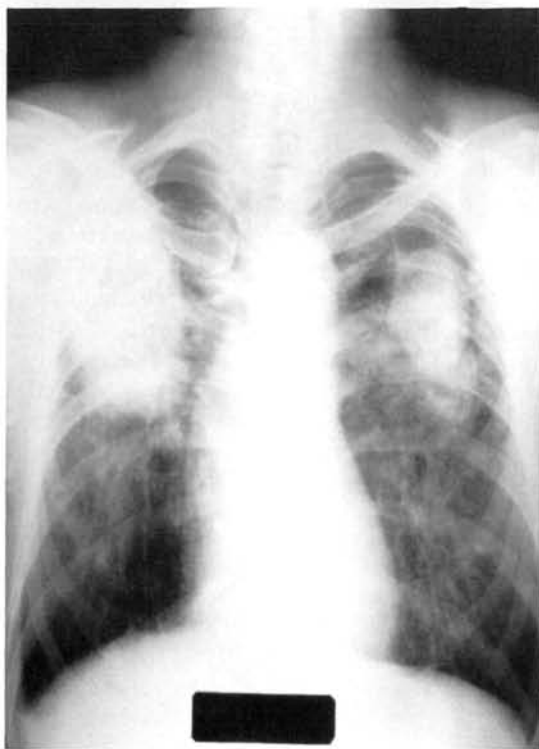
Chest radiograph of a patient with complicated silicosis, progressive massive fibrosis of both upper lung fields;
